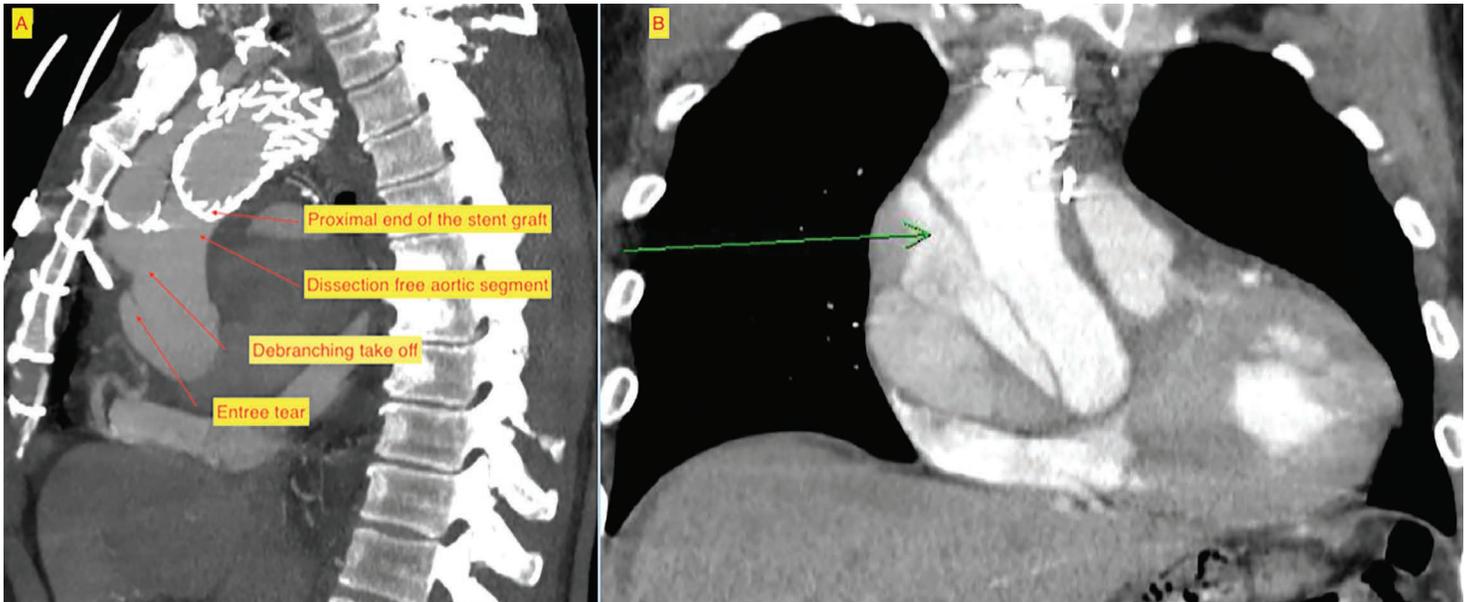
(A) Transverse computed tomography angiography (CTA) showing the dissected segment of the ascending aorta. (B) Sagittal CTA showing the entry tear of the dissection, debranching vessel, and disease-free segment of the aorta between the proximal landing zone and the debranching.
